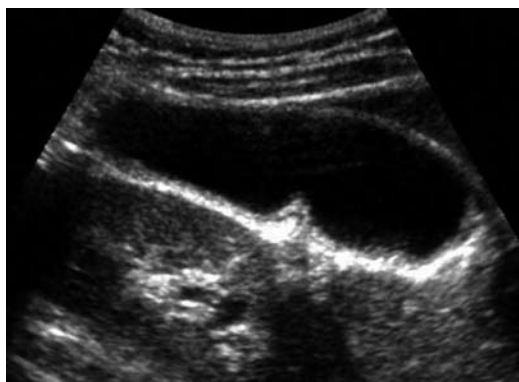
Abdominal ultrasound of a patient with pancreaticobiliary maljunction without biliary dilatation showing uniform smooth thickness of the gallbladder wall.
